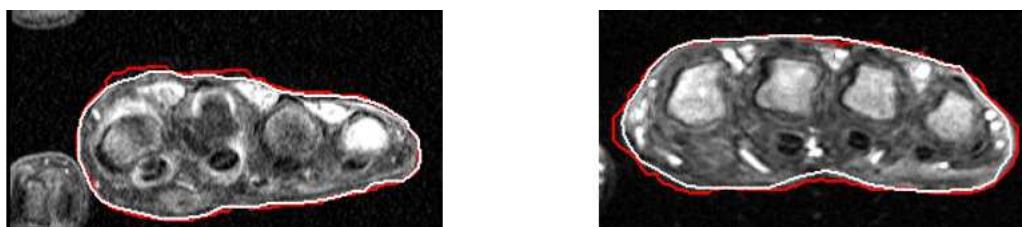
Post-contrast images from different DCE-MRI studies acquired with the high-field scanner, with the joints' envelopes segmented automatically (white) and manually (red).
